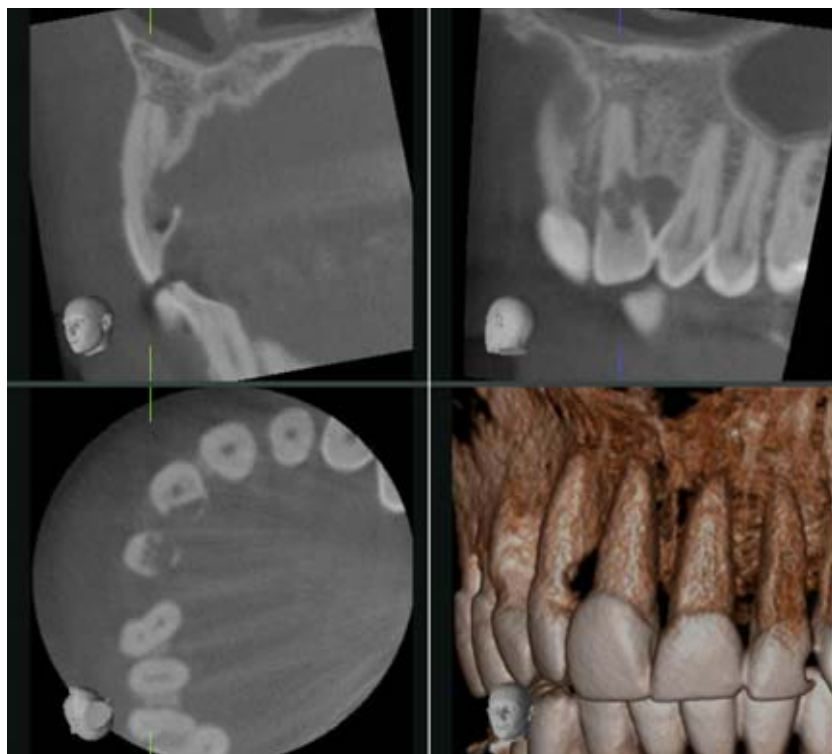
External invasive cervical resorption (EICR) tooth 12. Extension to the middle third of the root, circumferential extension $> 270^\circ$, possible pulp involvement: CBCT based classification tooth 12 = 3Dp; additionally tooth 11 affected = 2Bd.
